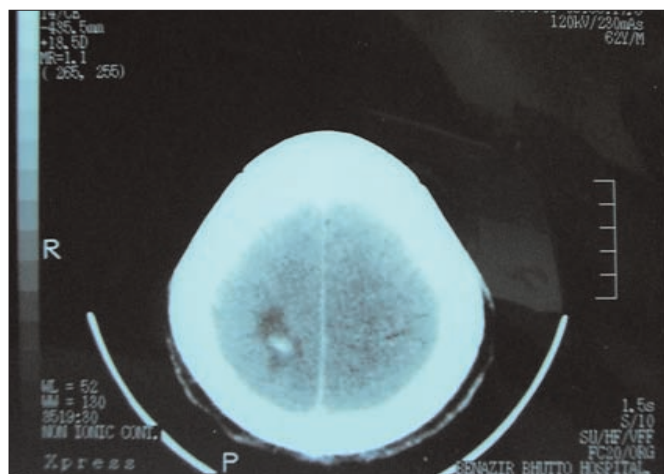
Showing CT scan done on 29th June 2009 showing area of reactive gliosis in the area previously occupied by SOL.
